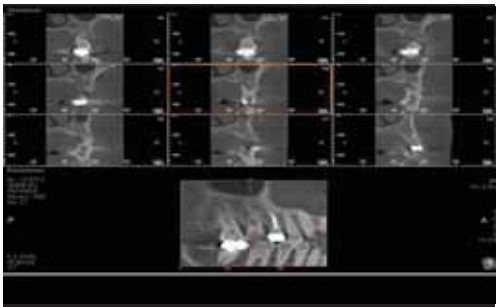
CT view of #16 & #17 shows bone loss around palatal root.
